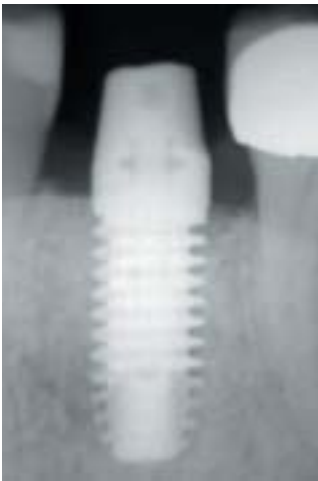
Radiograph at 1 year with restoration removed. Bone loss down to the first thread with radiographic integration.
